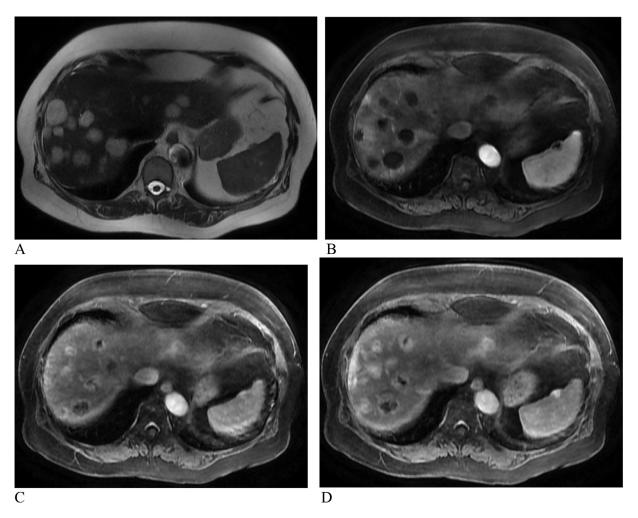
MRI of the abdomen with a pattern consistent with hemangiomatosis. A: The multiple hepatic lesions demonstrate hyperintense T2 signal. B: On the postcontrast images, the lesions demonstrate peripheral nodular arterial enhancement. C: The lesions slowly fill in with contrast on the portal venous phase. D: The lesions slowly fill in with contrast on the delayed phase.
